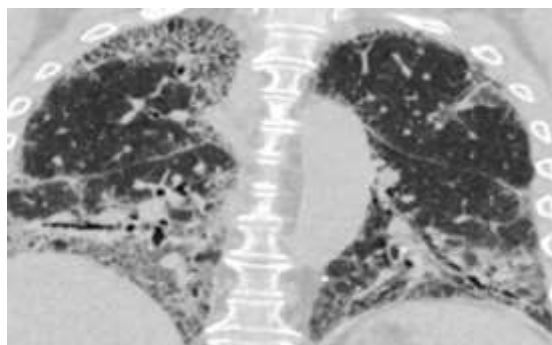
Architectural distortion. Coronal HRCT image of the chest demonstrates reticulations, traction bronchiectasis, and architectural distortion.
